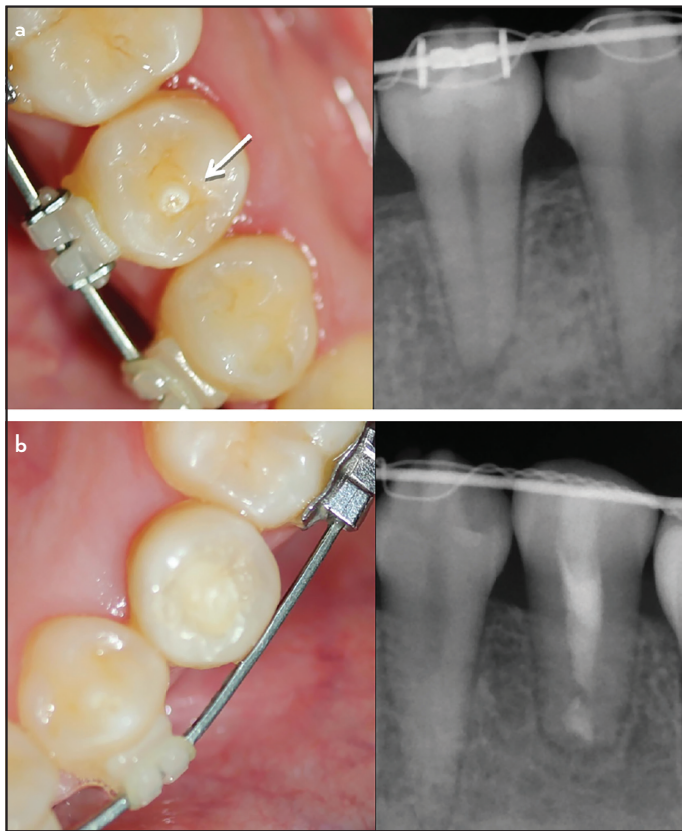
(a) Clinical photograph showing an occlusal tubercle consistent with dens evaginatus in 4.5 and periapical radiograph. (b) Occlusal view of the occlusal filling in 3.5, and periapical radiograph 1 year after having received apical surgery. Arrow indicates DE tubercle
